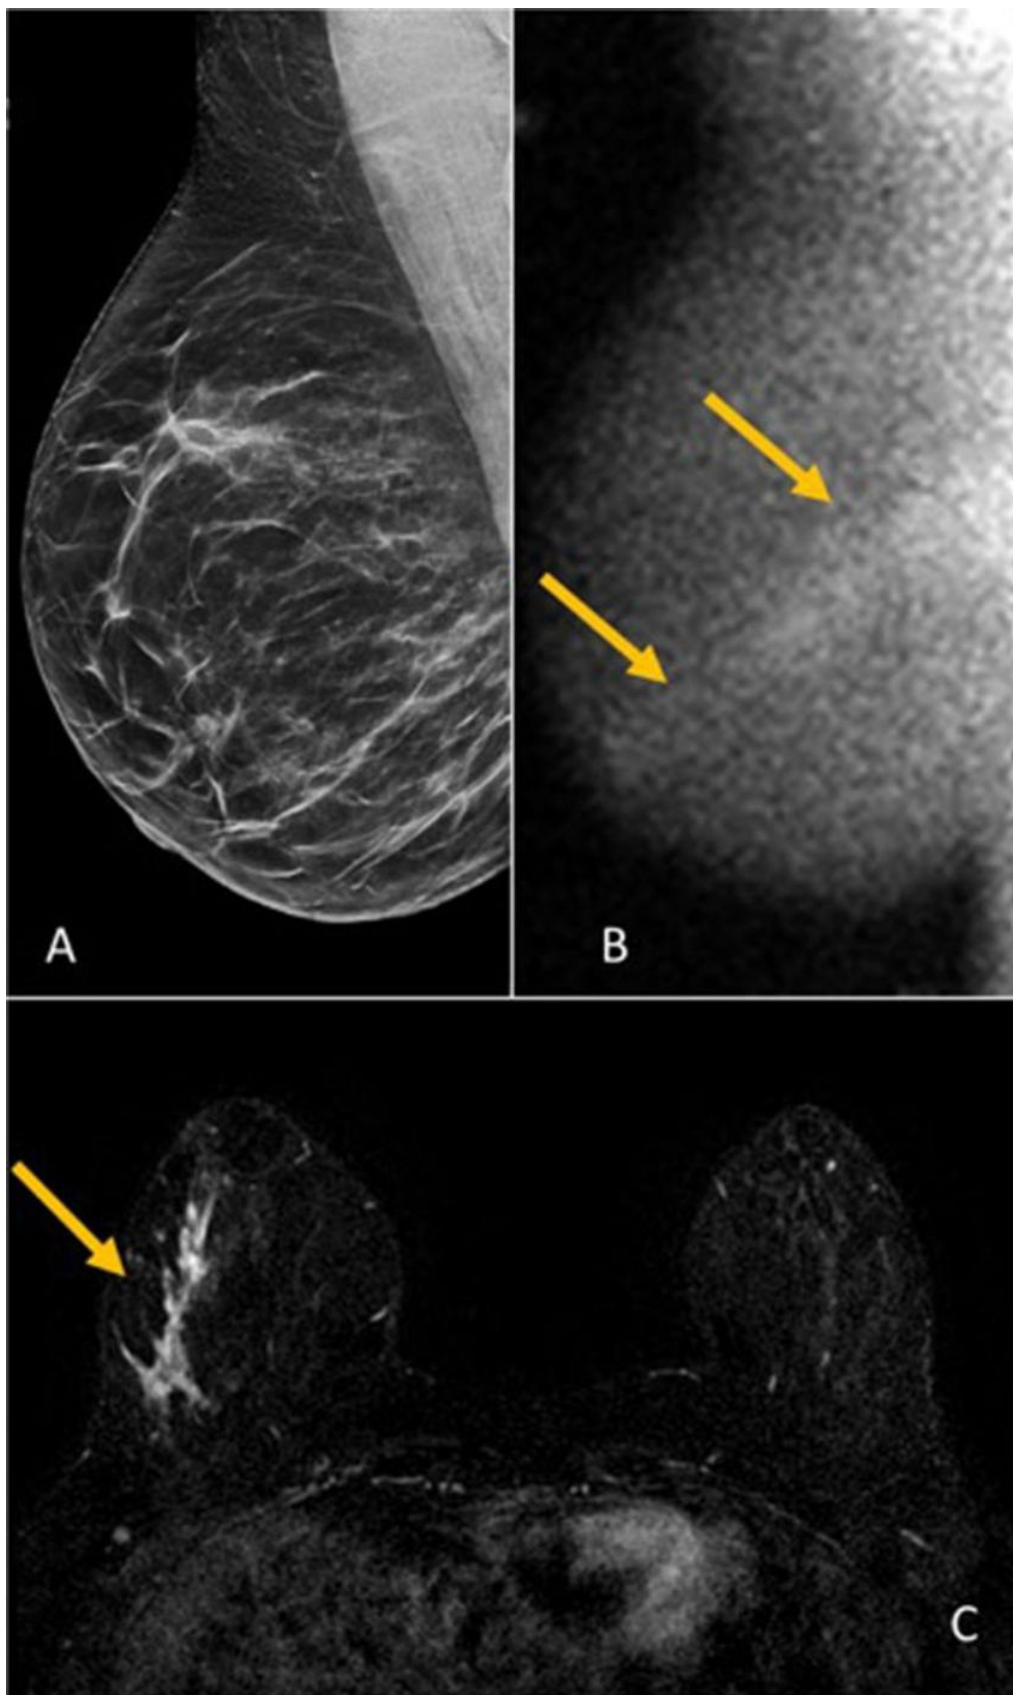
Images in a 48-year-old woman who presented for screening. (A) Image from digital breast tomosynthesis screening (synthesized two-dimensional mediolateral oblique view of the right breast) at year 1 was interpreted as negative and showing heterogeneously dense breast. (B) Image from molecular breast imaging screening (mediolateral oblique view) at year 1 reveals a nonmass segmental area of uptake in the right breast (arrows). (C) Contrast-enhanced MRI scan (subtraction maximum intensity projection) shows corresponding segmental nonmass enhancement measuring 9.8 cm to the greatest extent (arrow). MRI-guided core biopsy and lumpectomy revealed high-grade ductal carcinoma in situ, 2.5 cm in extent, estrogen receptor-negative, and progesterone receptor-negative lesions.
